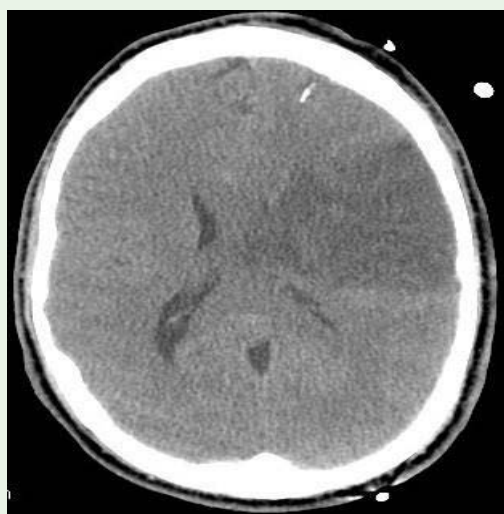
Axial non contrast CT image (5 mm) showing a left located MCA infarct.
